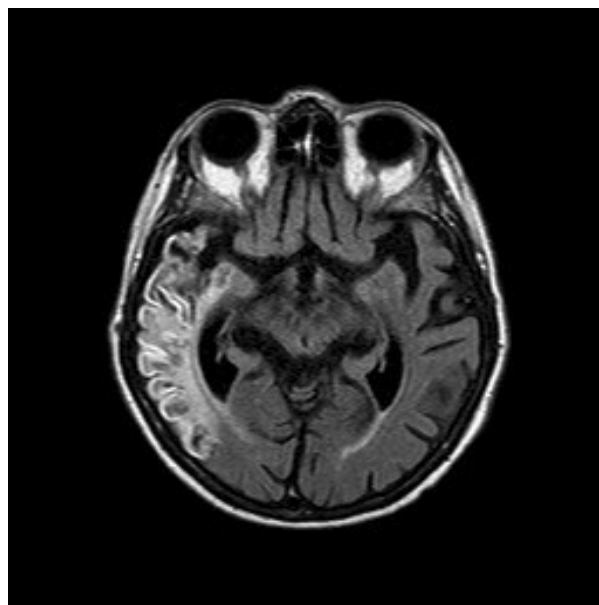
Patient no. 1 - FLAIR sequence showing post-ischemic encephalomalacia in the right occipital and temporo-occipital cortex.
